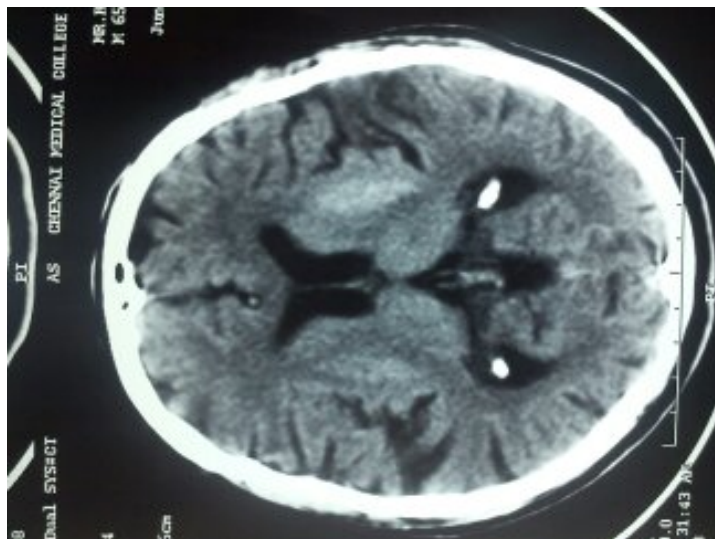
Brain CT showing hyperdensity in the region of the putamen.
